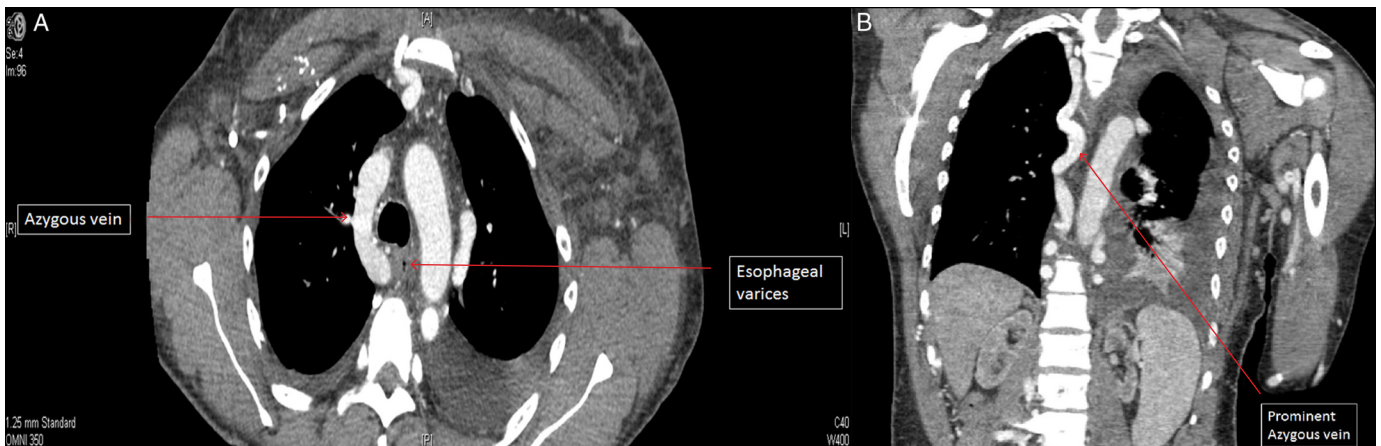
Computed tomographic angiogram of the chest demonstrating (A) dilated azygous vein and midesophageal varices and (B) dilated azygous vein and chest wall collateral vessels.
